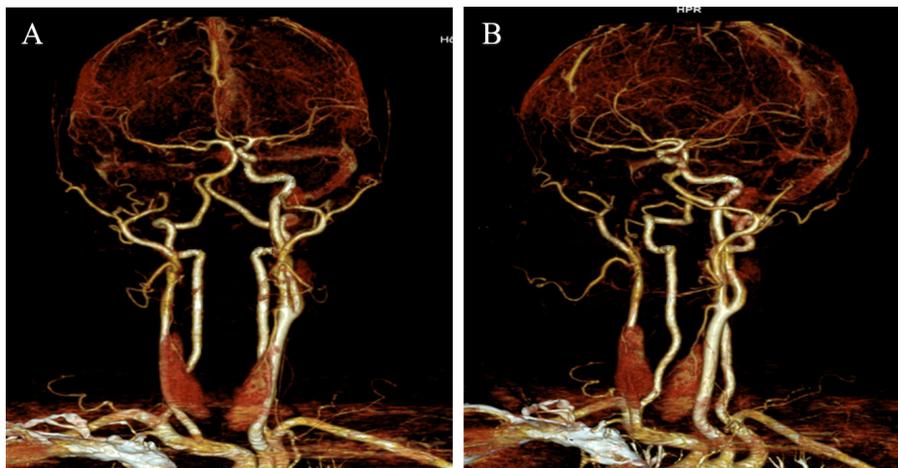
Angio-CT showing the absence of the right internal carotid artery.
